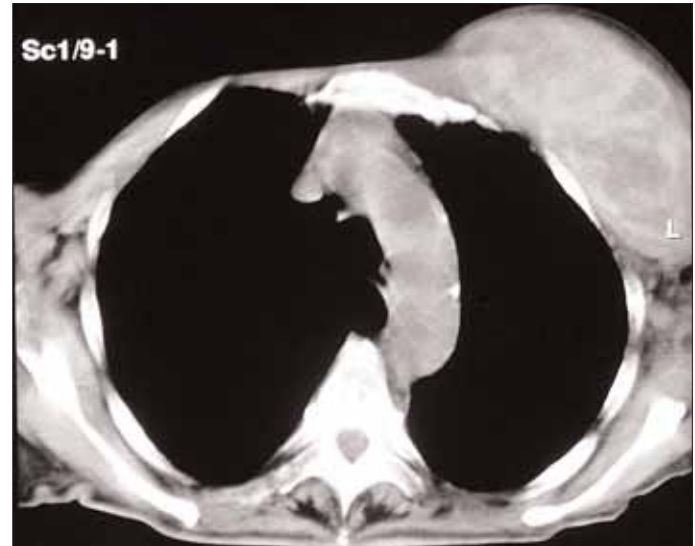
Computed tomography of thorax showing left pectoral hematoma
